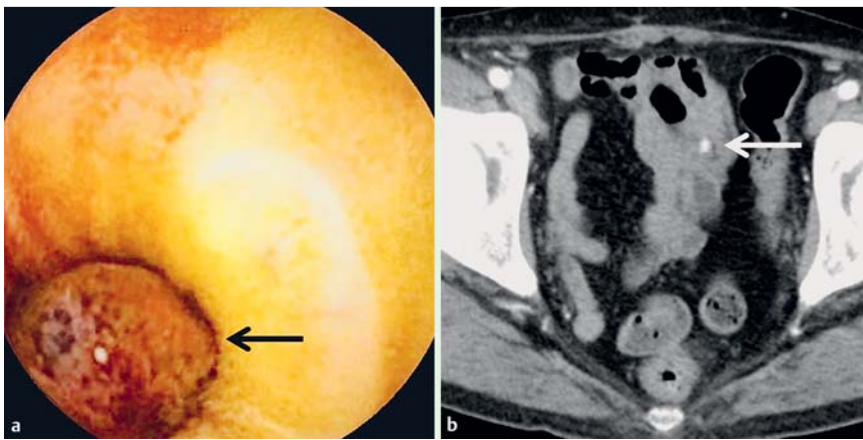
a Wireless capsule endoscopy showing a reddish elevated lesion in the jejunum (black arrow). b Contrast-enhanced computed tomography of the abdomen and pelvis showing the mass exhibiting enhancement (white arrow).
